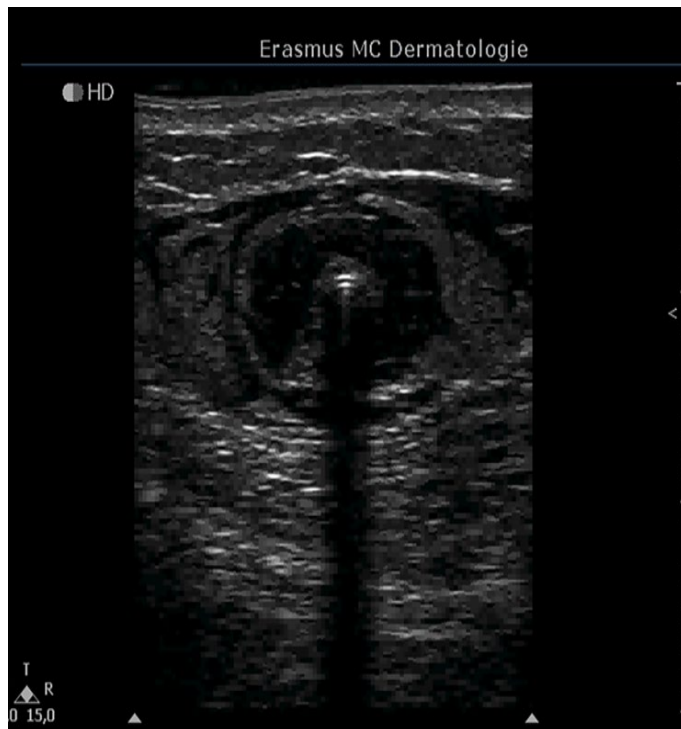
duplex ultrasound image showing the catheter (yellow arrow) surrounded by tumescent anaesthesia (within blue circle)
